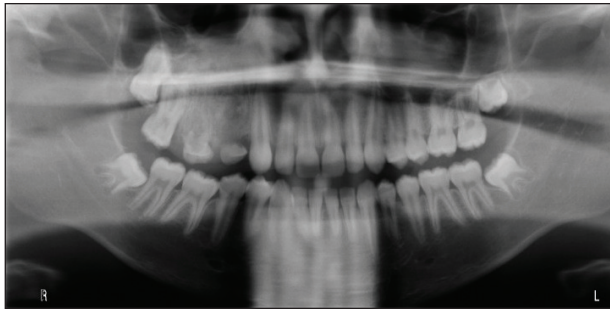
Dental radiograph demonstrated hyperplasia of the right maxillary alveolus and basal bone area with 2 missing permanent teeth (fourth and fifth premolars).
